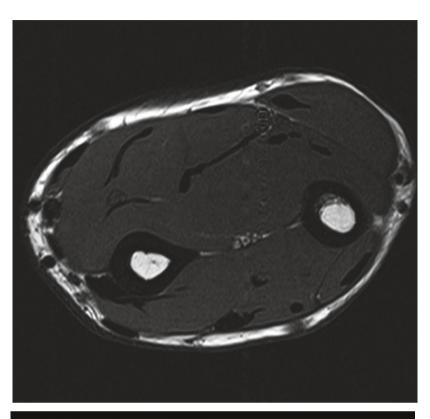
MRI scans in the elbow through the ulnar nerve
